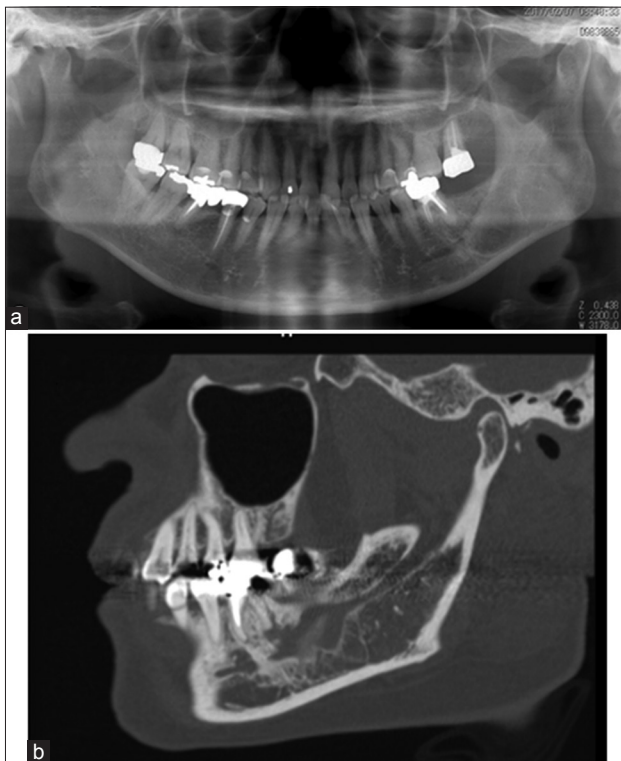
Postoperative panoramic radiograph (a) and computed tomography (b) 1 year after removing the tumor
